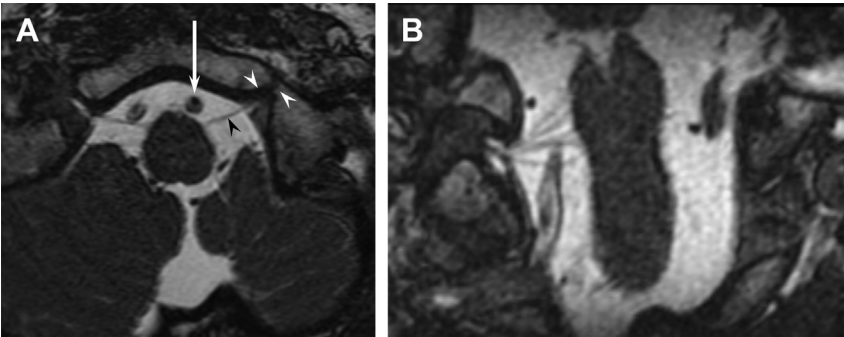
Cisternal course of hypoglossal nerve. (A) Axial SSFP MRI shows the oblique course of the hypoglossal nerve (black arrowhead) as it crosses the lateral cerebellomedullary cistern toward the hypoglossal canal (white arrowheads). The vertebral artery (arrow) is anterior to the nerve. (B) Coronal SSFP image reveals the numerous nerve rootlets that compose right CN XII.
